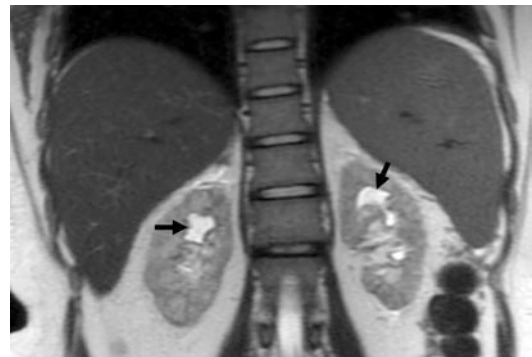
Hepatosplenomegaly in disseminated tuberculosis. Coronal T2-W MR image shows disseminated and miliary tuberculosis presenting as hepatosplenomegaly. Both kidneys are heterogeneously hyperintense with irregular parenchymal thinning and asymmetrical hydrocalycosis (black arrows). (Courtesy of Dr. Ashok Mithra, Naruvi Hospital, Vellore, India)
